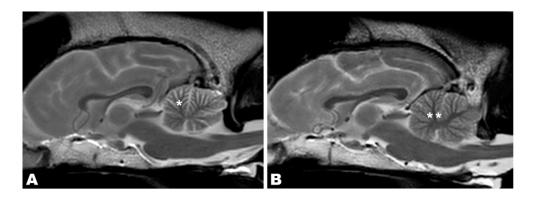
Sagittal T2-weighted magnetic resonance imaging (MRI) from a 4-year-old female spayed Staffordshire terrier (A) that was evaluated for progressive ataxia and episodes of collapse that localized to the cerebellum. Note the cerebellar cortical atrophy characterized by secondary widening of the cerebellar sulci with cerebrospinal fluid (CSF), outlining hypointense white matter tracts (*). These findings are consistent with cerebellar cortical degeneration of American Staffordshire terriers. Sagittal T2-weighted MRI from an age and weight matched normal Labrador Retriever (B) with idiopathic (suspected genetic) epilepsy showing normal cerebellar structure for comparison. Note the abundance of visible cerebellar cortex () between hypointense white matter tracts, with minimal CSF in the cerebellar sulci.
